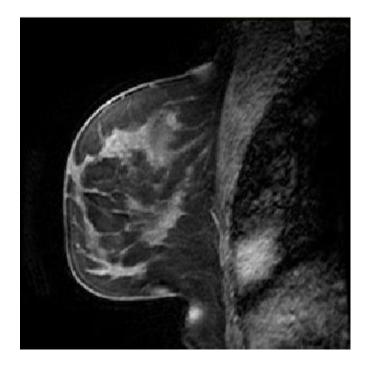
Original MR image of a normal patient. Image acquired at 2 minutes post contrast using a high resolution 3D T_1 weighted sequence. Patient is a 39 years old female
